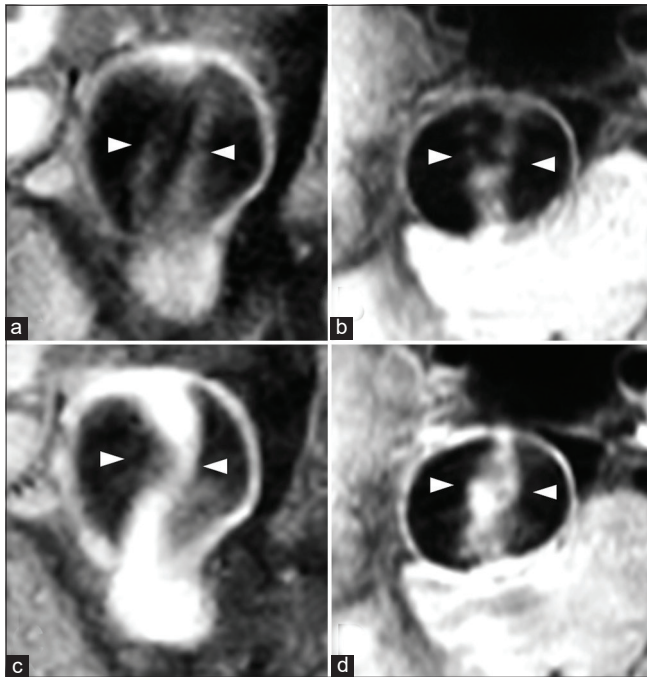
Magnetic resonance imaging (MRI) findings 6 years from the first diagnosis. Coronal (a) and axial (b) noncontrast volumetric isotropic turbo spin echo acquisition (VISTA) MRI and coronal (c) and axial (d) contrast VISTA MRI showing blood flow in the pseudolumen and changes in image findings of the intimal flap with enhancement. The intimal flap looks like it split into two (arrowhead).
